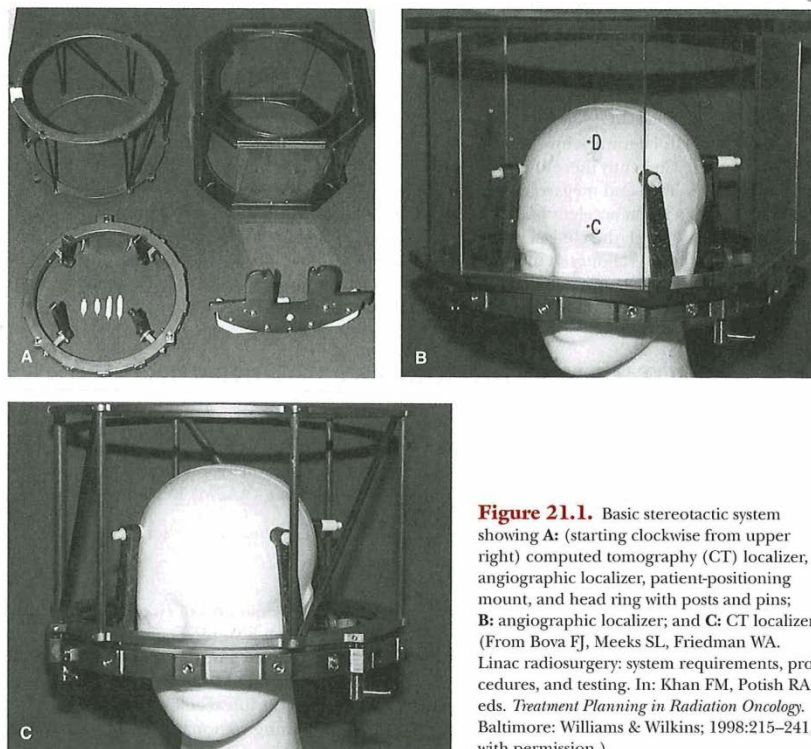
Basic stereotactic system showing A: (starting clockwise from upper right) computed tomography (CT) localizer, angiographic localizer, patient-positioning mount, and head ring with posts and pins; B: angiographic localizer; and C: CT localizer. (From Bova FJ, Meeks SL, Friedman WA. Linac radiosurgery: system requirements, procedures, and testing. In: Khan FM, Potish RA, eds. *Treatment Planning in Radiation Oncology*. Baltimore: Williams & Wilkins; 1998:215–241, with permission.)
